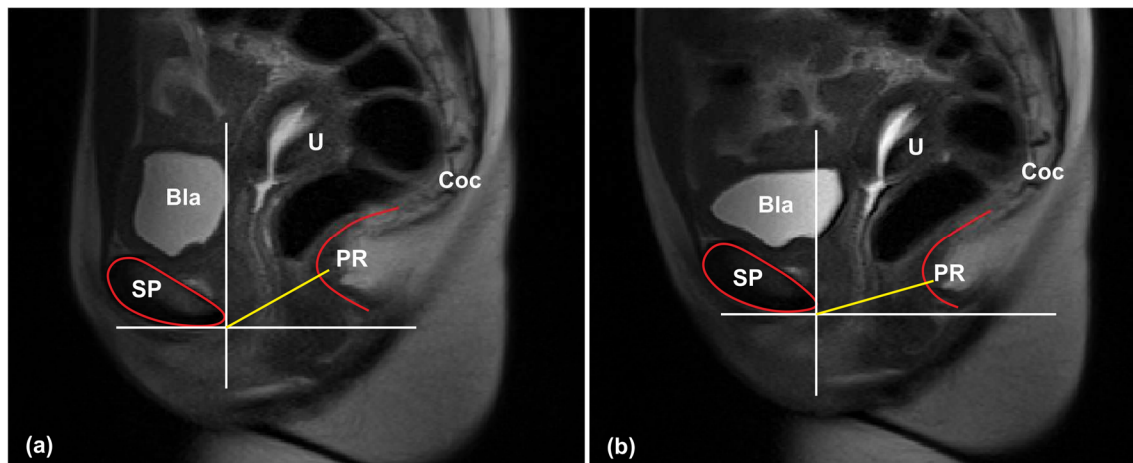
MR images in the mid-sagittal plane acquired at rest (a) and at maximal Valsalva manoeuvre (b). The main pelvic structures are identified (Bla - bladder; Coc - coccyx; PR - *puborectalis* muscle; SP - *symphysis pubis*).
